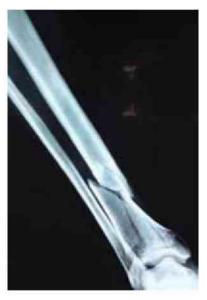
X-ray of leg with ankle anteroposterior view showing tibial plafond fracture. Note the discontinuity of the tibial plafond (distal articular surface) due to a compression injury at the ankle.
